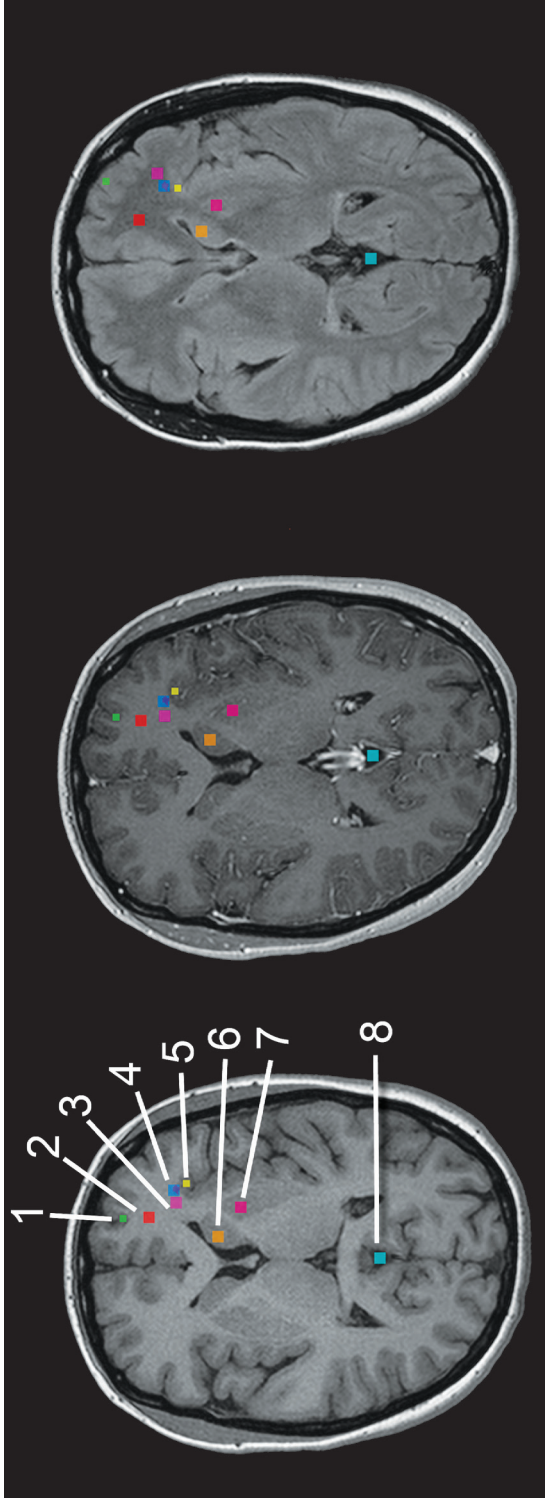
Brain images from the basal ganglia, with ROIs indicated on the images. Left, T1w MPR image; centre, T1w MPR image; right, T1w MPR image acquired with contrast agent; right, FLAIR image. Different ROIs are indicated by numbers and colours: 1) green, centre, T1w MPR image; 2) red, white matter; 3) pink, normal-appearing white matter; 4) blue, MS plaque (10x10 ROI) and violet, hand-drawn MS plaque; 5) yellow, cortex near lesion (normal-appearing grey matter); 6) orange, nucleus lentiformis and 8) aquamarine, cerebrospinal fluid.
